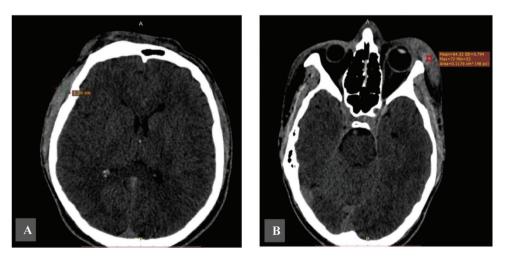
Cranio-cerebral CT scan: right fronto-parieto-temporal epicranial hematoma (12 mm thickness) (A); left palpebral hematoma (B).
